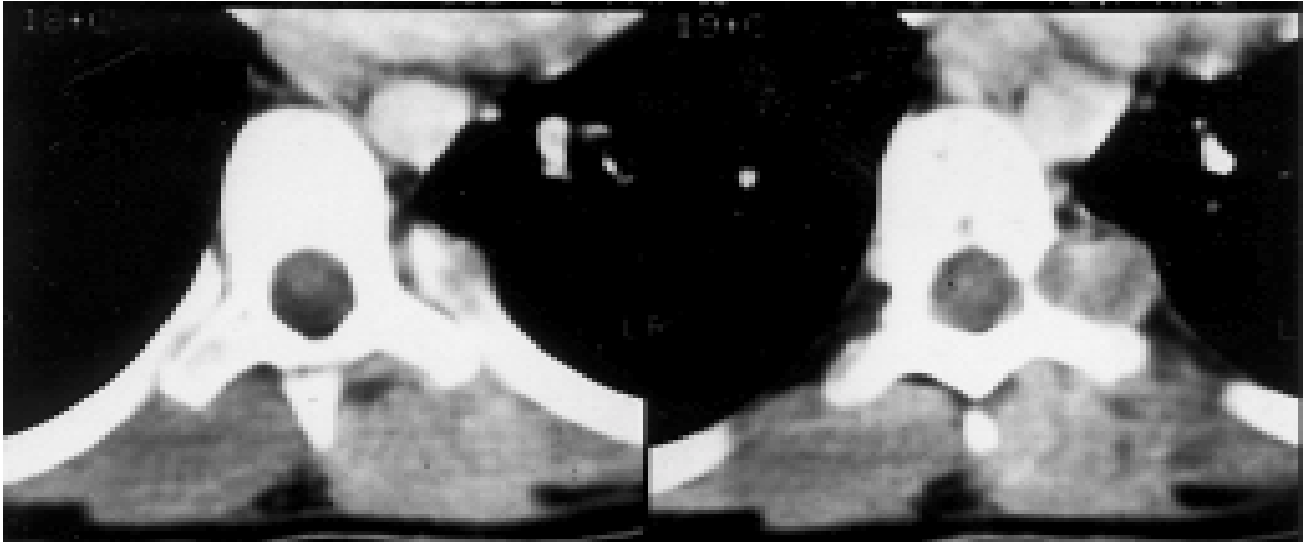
CT scan at the level of T8: The paraspinous soft tissue extended into the intervertebral foramen below, but did not encroach upon the contents of the spinal canal.
